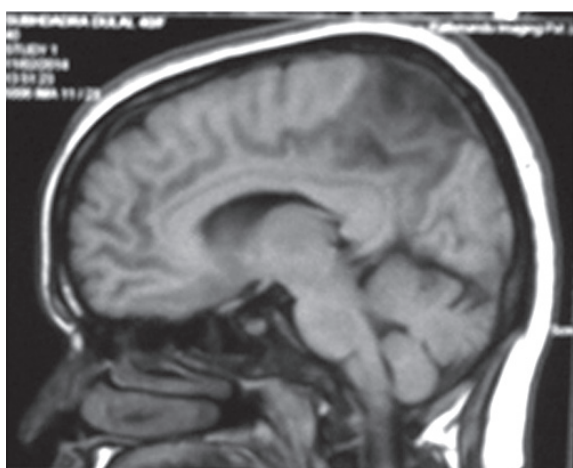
Magnetic resonance imaging of head showing mass lesion
